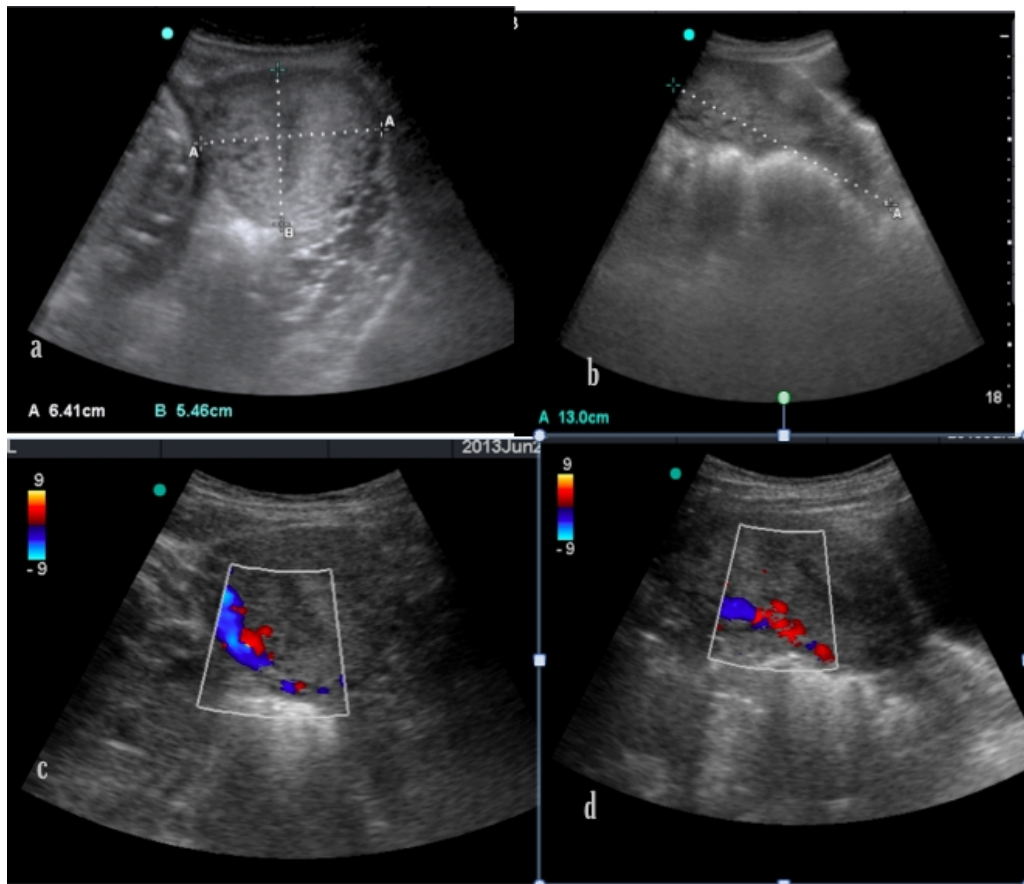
Antenatal Ultrasound images of 23 years old female with uterine didelphys at 36 weeks 3days.Gross enlargement of left uterus as compared to non-pregnant state and increased blood flow in left uterus on Doppler study (figures c & d)
